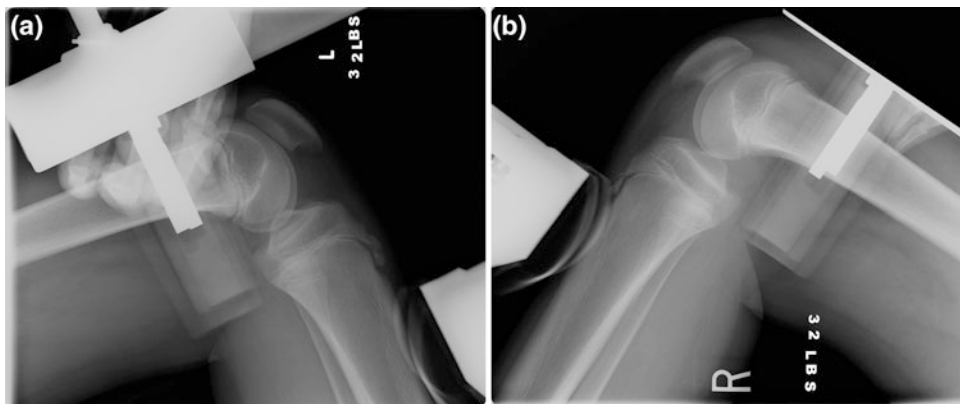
Preoperative stress radiography with a posteriorly directed force applied to the proximal tibia of the normal uninjured knee (a) and the PCL, posterolateral, posteromedial injured knee (b). These stress radiographs demonstrate increased posterior translation at approximately 90° of knee flexion in the injured knee compared to the normal
